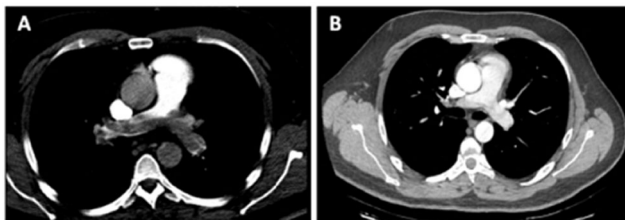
Multi-detector computed tomography pulmonary angiogram revealing a proximal and bilateral artery pulmonary embolism (A) with a dramatic regression after thrombolysis (B)
